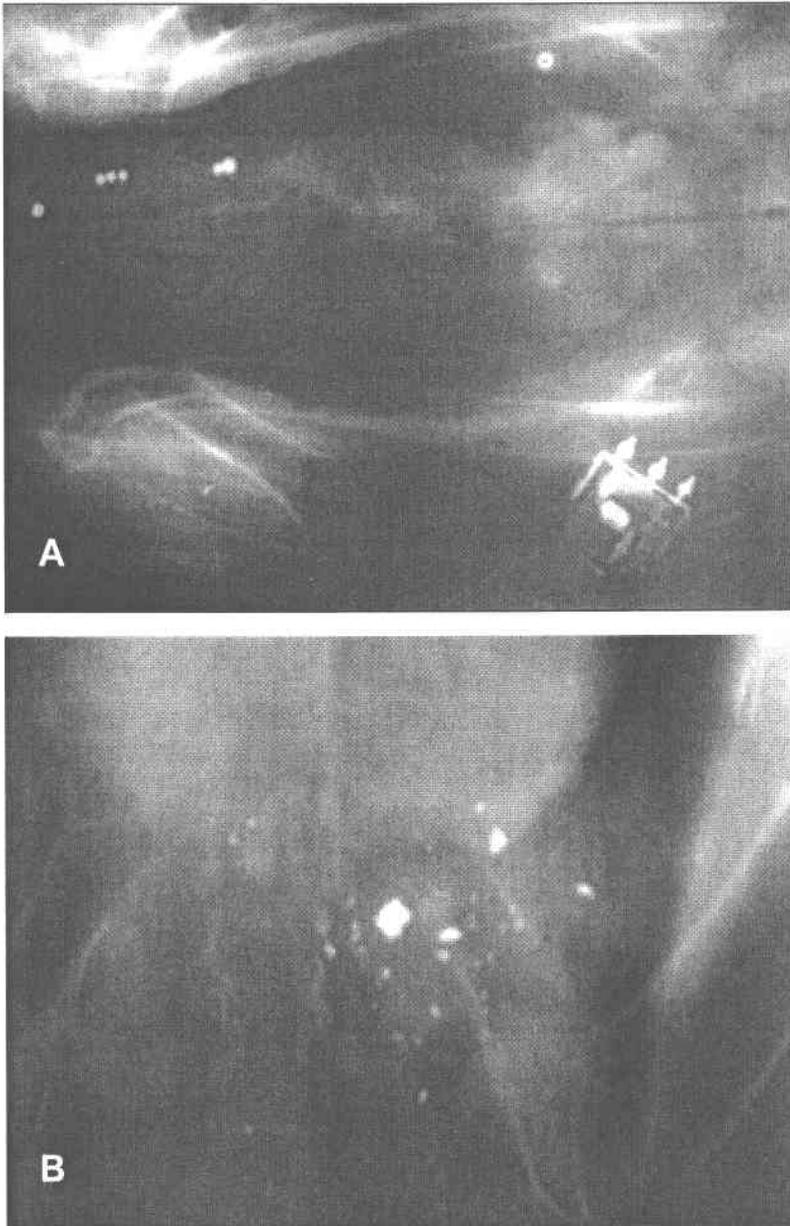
(A) Radiograph of the digestive tract of condor SB #165 containing lead shotgun pellets of two sizes. Lead poisoning was the diagnosed cause of death (VHF transmitter visible). (B) Radiograph of condor SB #243's stomach containing lead bullet fragments; its blood lead level four days later showed $691 \mu\text{g dL}^{-1}$.
